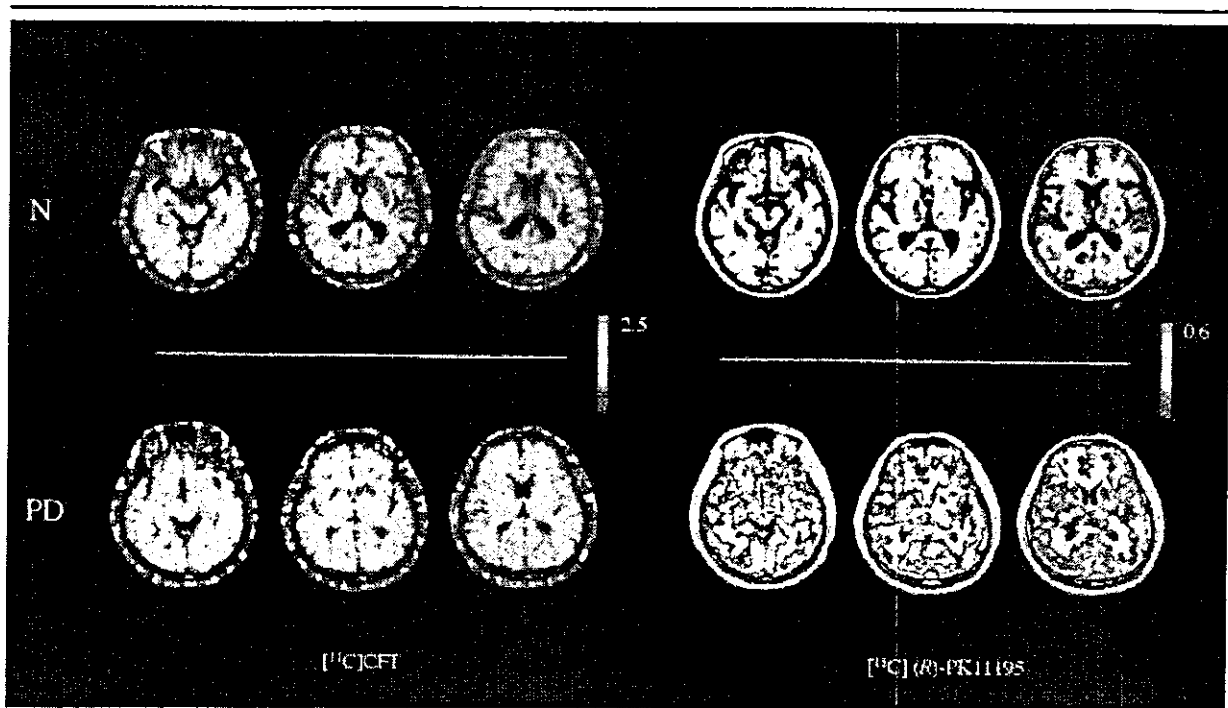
Magnetic resonance imaging positron emission tomography fusion parametric images of [¹¹C]CFT accumulation normalized to the cerebellum and [¹¹C](R)-PK11195 binding potential in a healthy subject (N) and a Parkinson's disease patient (PD) rated as Hoehn & Yahr stage 2. A marked increase in [¹¹C](R)-PK11195 binding was observed in the midbrain contralateral to the more disabled side along with a reduction in [¹¹C]CFT uptake in the putamen in the PD patient. For each tracer, red represents the highest value and dark violet represents the lowest value.
